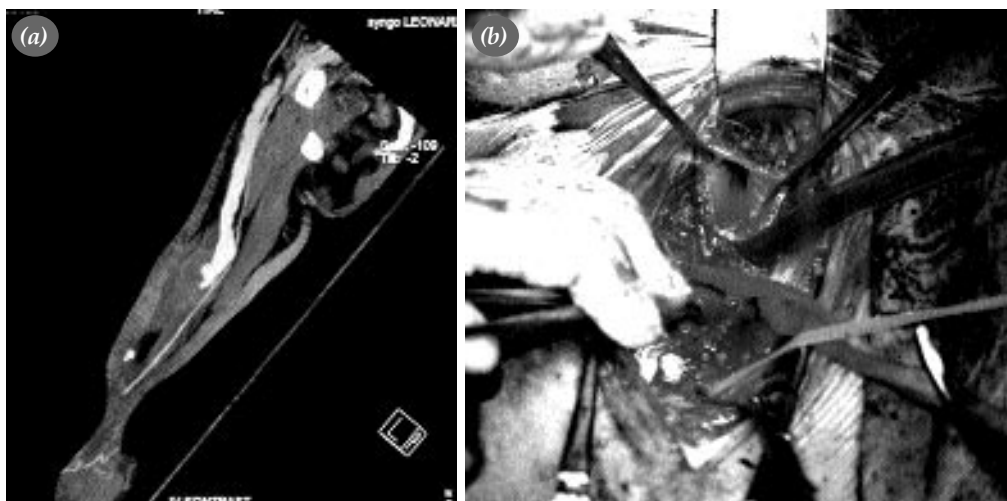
(a) Computed tomography angiography revealed primary aneurysm of the xenograft. (b) Intraoperatively, the proximal end of the aneurysmatic xenograft measured 2.9 cm.
